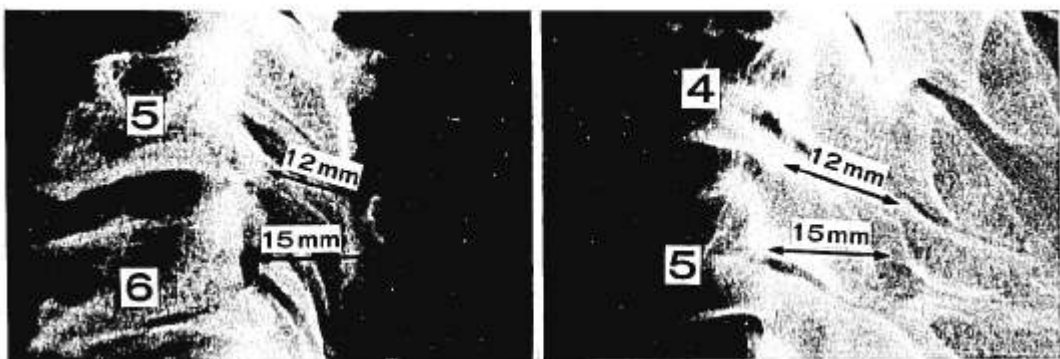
Lateral roentgenograms, showing dynamic AP canal diameter reduced to 12 mm by posterior osteophytes at C5-6 (left), and by retrolisthesis at C4-5 (right) in subjects with normal static AP canal diameters (15 mm).
